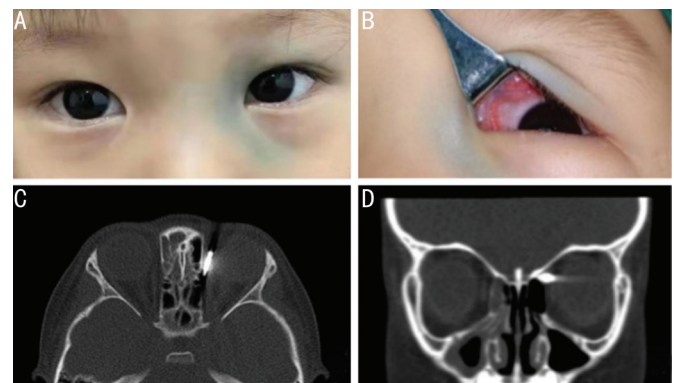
Children with preoperative check the photos A: Appearance in addition to the upper eyelid and inner canthus of peri-orbit skin cyan without other symptoms; B: The eyelid retractor opened the upper eyelid, and the blue conjunctiva was seen in the fornix region above the nose. C: Orbital CT scan preoperatively, left eye close orbital wall is seen here in a rod-shaped high-density shadow, visible around the metal radial artifacts; D: Preoperative orbital CT coronal scan, oval high-density shadow was seen above the medial rectus muscle at the equator of the eyeball. CT: Computed tomography.
